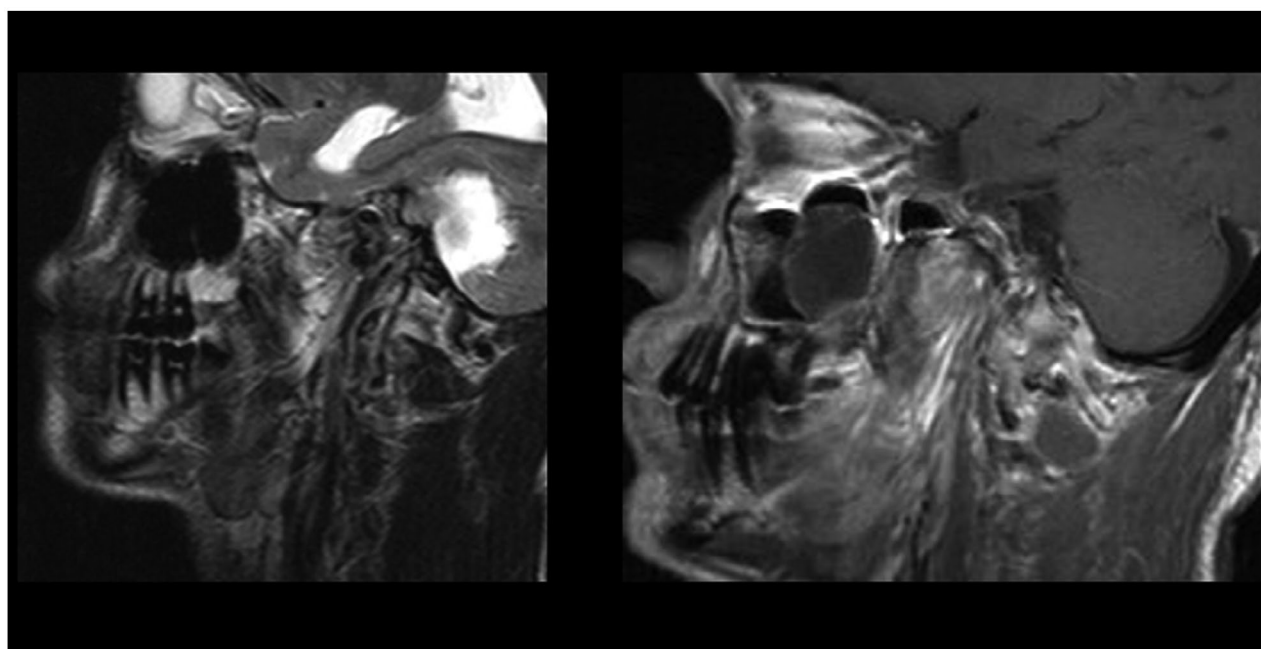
Sagittal magnetic resonance (MR) T1 and T2-weighted MR images showing maxillary sinusitis.
